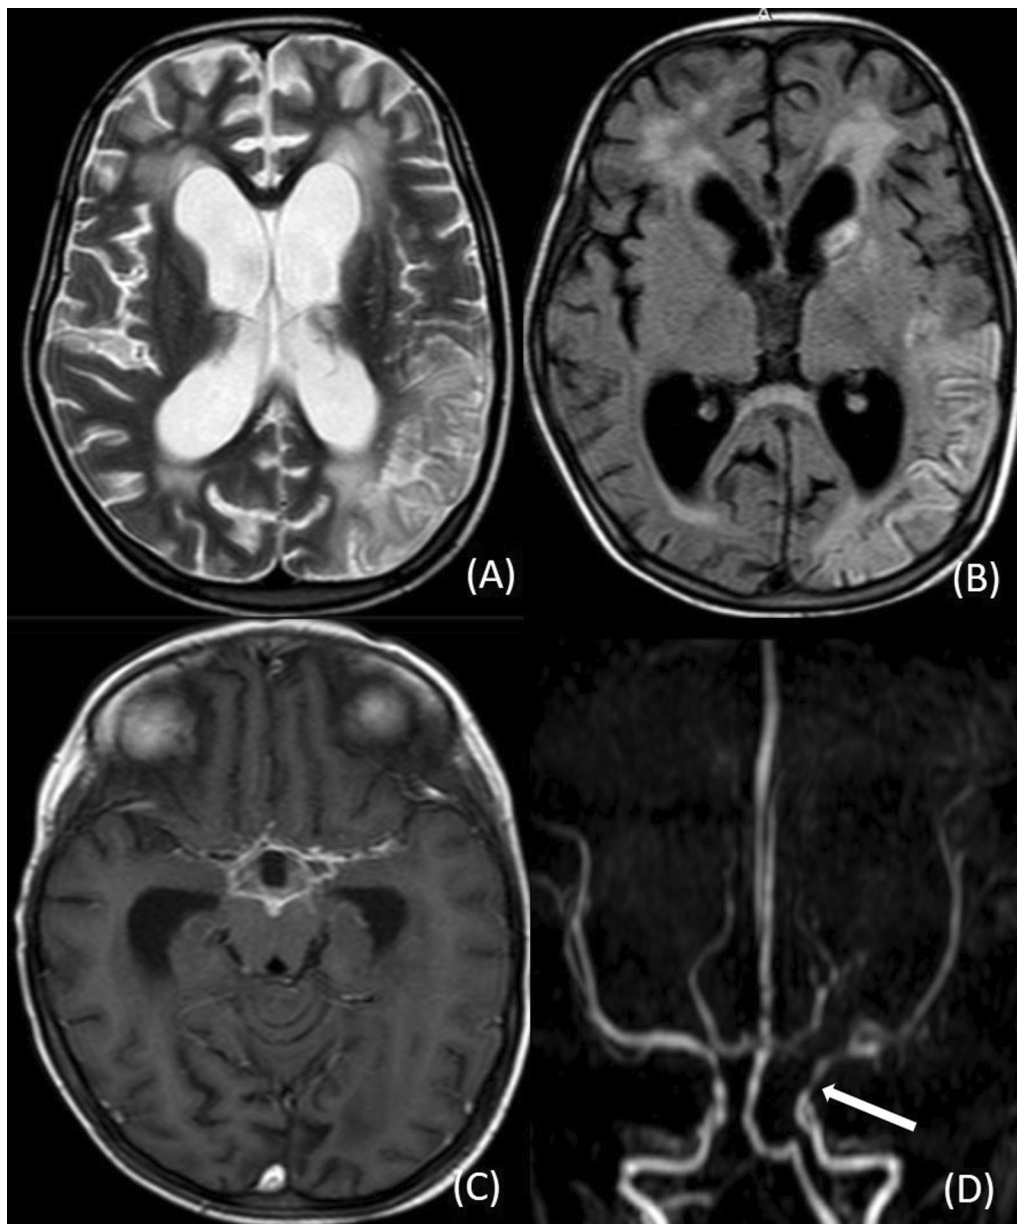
CNS TB with moyamoya vasculopathy and infarction in left MCA territory. MRI of a 5-year-old girl shows hyperintensity involving both grey and white matter in left MCA territory on T2W (A) and FLAIR image (B) with communicating hydrocephalus (A and B), T1 contrast-enhanced image shows exudates in basal cistern and left sylvian fissure (C), MR angiography shows attenuated supraclinoid segment of left ICA and left MCA (white arrow in D)
